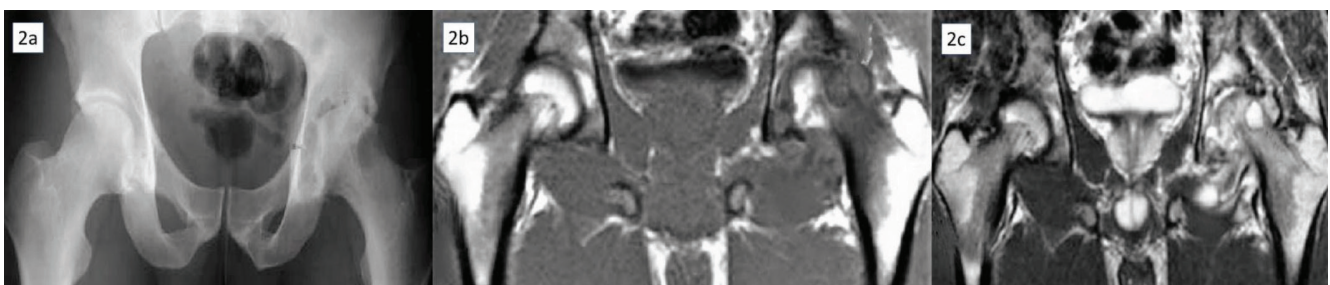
Case of left femoral hip joint tuberculosis. AP radiograph of pelvis (2a) showing erosions on both sides of left femoral head with joint space narrowing. Coronal T1W (2b) and T2W (2c) MR images showing large joint effusion, marrow edema, erosive changes and also edema of the obturator externus on left side
